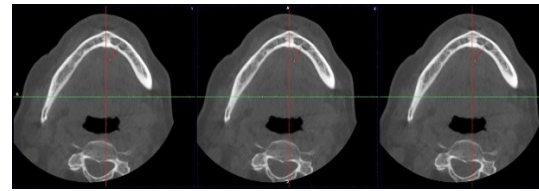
LLF observed in CBCT images is shown with a red arrow in consecutive axial sections.
